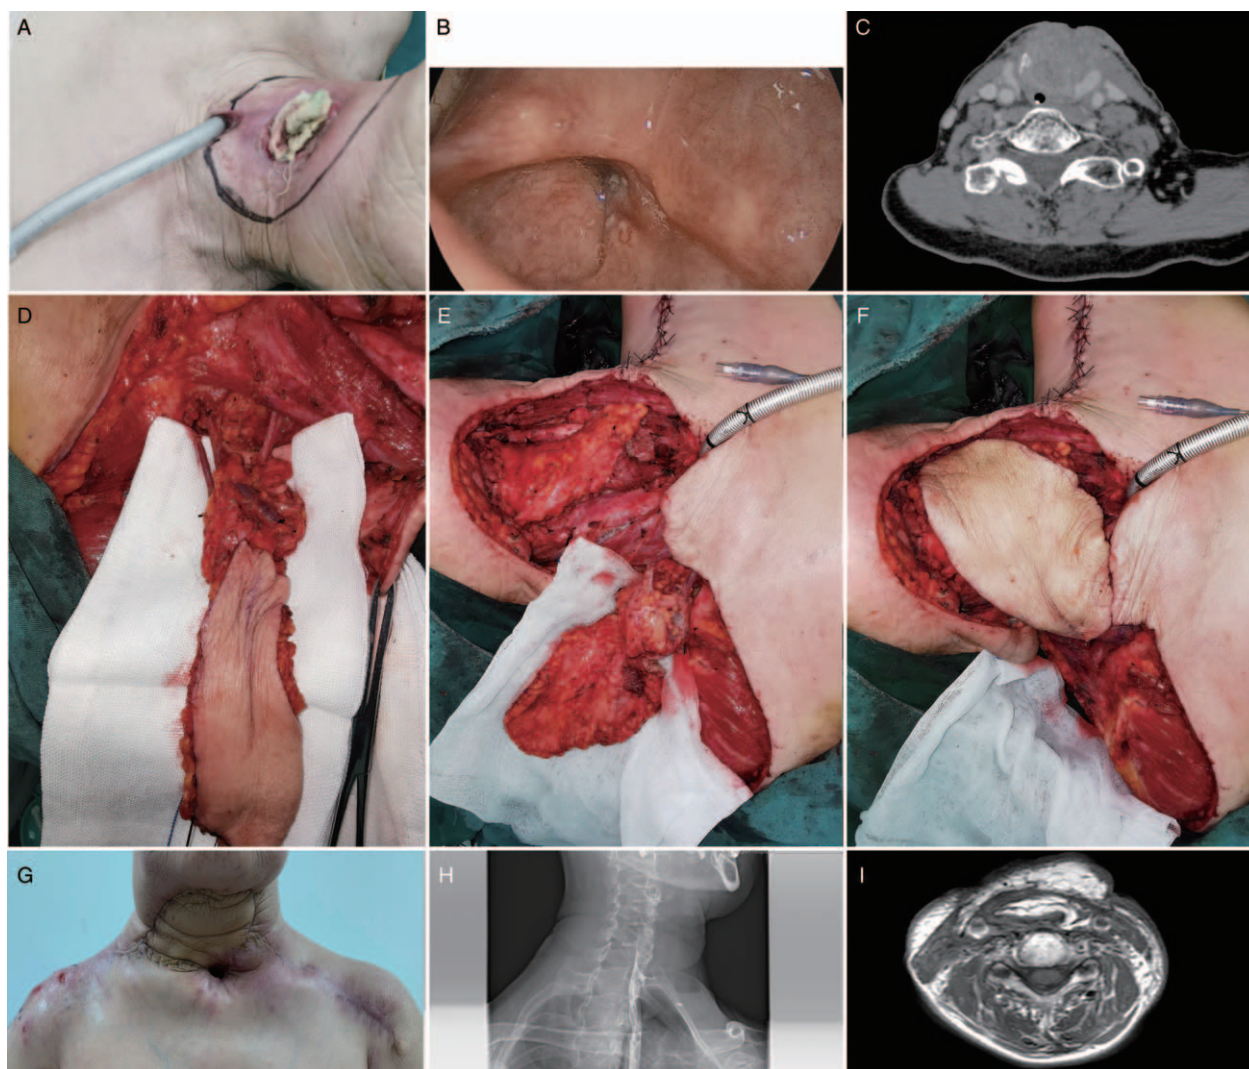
(A) Physical examination: swelling of the front neck, skin ulcers, ruptured area of about 2 cm × 1 cm. (B) Laryngoscopy: local glottic scar-like changes. (C) Neck computed tomography: axial view: Irregular soft-tissue masses can be seen in the laryngo-pharyngeal cavity, about 4.9 cm × 3.6 cm in size. (D) The lesions involved the skin of the neck and the left cervical sheath. Left supraclavicular artery island flap, 7 cm × 4 cm. (E) Right supraclavicular artery island flap, 10 cm × 7 cm. (F) The left skin flap was sutured to the posterior wall of the hypopharynx to repair the mucosal defect. The right skin flap was used to repair the anterior neck skin defect. (G) Appearance after repair. (H) Esophagography showed no stenosis 1 month after the operation. (I) Neck magnetic resonance imaging: axial view showed no significant flap atrophy 6 months after the operation.
